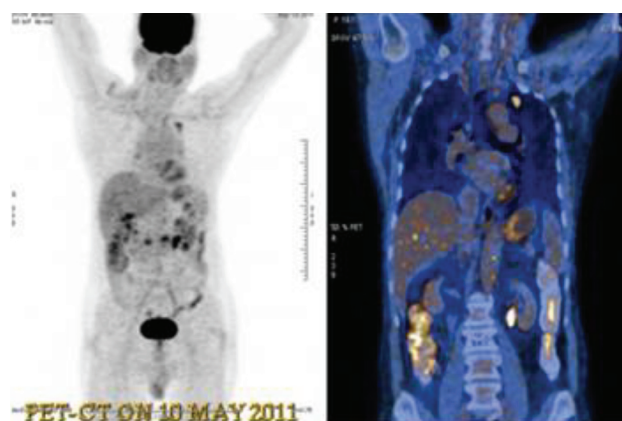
PET – CT done in May 2011 showing generalized adenopathy with increased uptake in the nodes.
